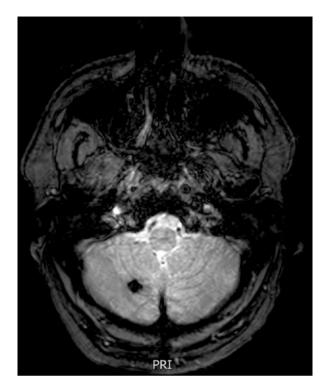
Axial cranial MRI, T2 fat-saturated sequence, showing a smaller cavernoma $(0.66 \times 0.98 \text{ cm})$ in the right cerebellar lobule
